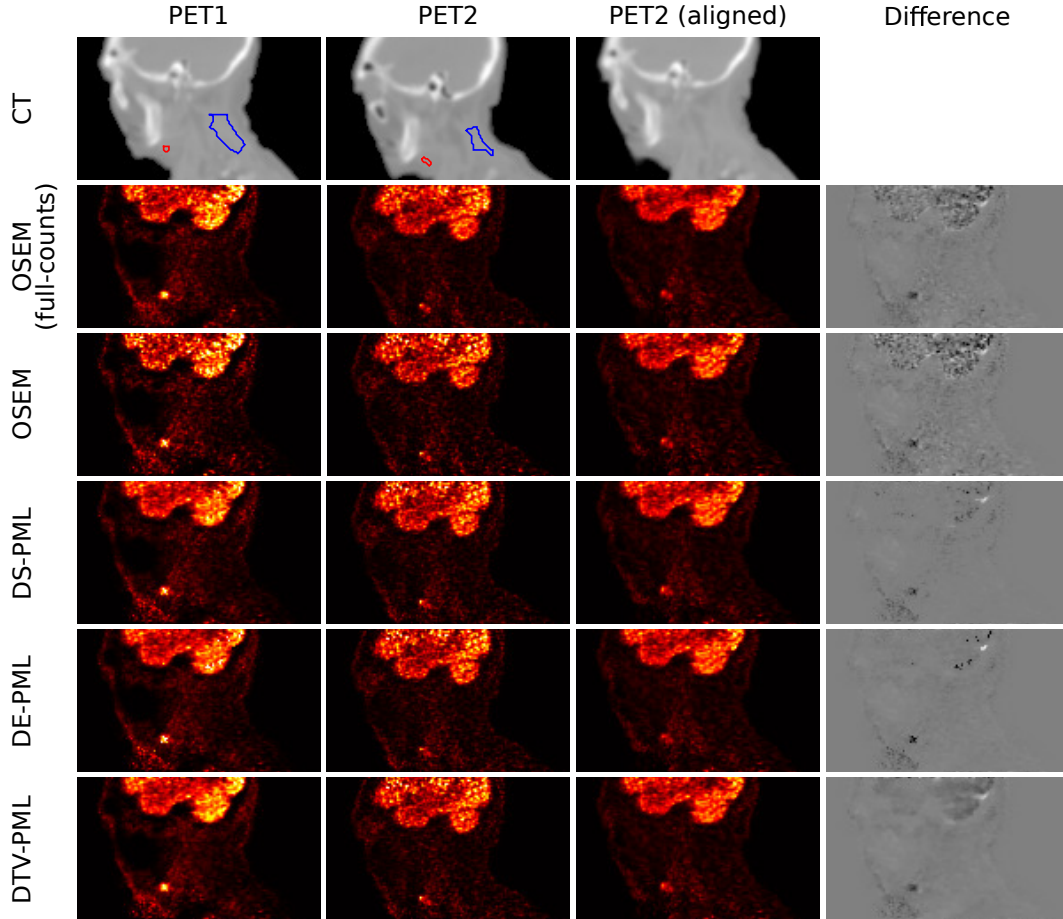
Example images for the real data case study. From left to right: PET1 images in their native space; PET2 images in their native space; PET2 images aligned to the PET1 image space; and difference images in the PET1 image space (i.e. column 3 minus column 1). Top row shows CT images with tumour (red) and background (blue) regions of interest shown for reference. PET reconstructions include the double-counts OSEM reconstructions, OSEM reconstructions, and reconstructions using DS-PML, DE-PML and DTV-PML, each with β values as indicated in Figure 4.16. These latter three difference-image prior methods reduce noise in the background of the image while maintaining the visual appearance of the tumour. Each also displays a distinctive difference image reflecting the characteristics encouraged by each prior.
